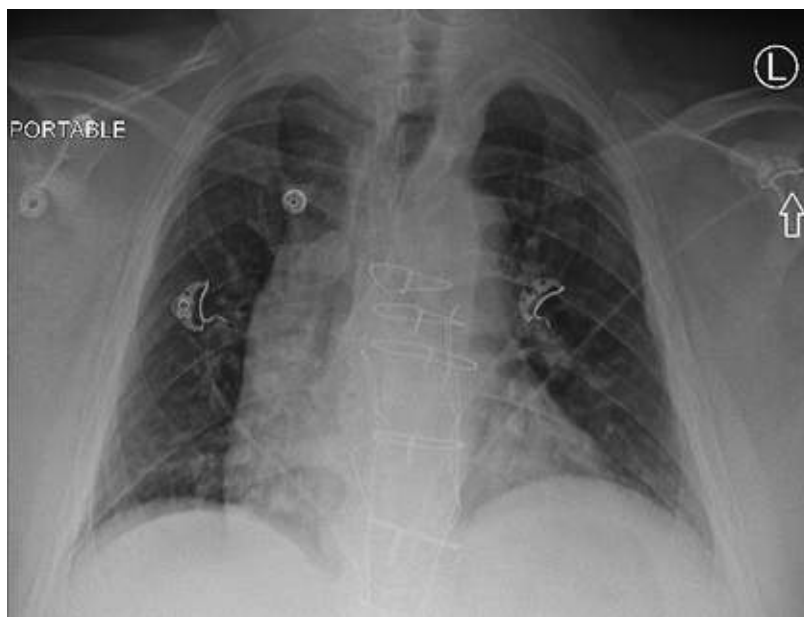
Limitations of portable technique. Portable radiograph shows an apparent large right atrial contour and a mediastinal widening to the right of the spine. Comparison with a standard PA chest radiograph obtained the previous day (see eFig. 15.3A) would reveal that these apparent abnormalities were caused by the portable technique and patient rotation.
